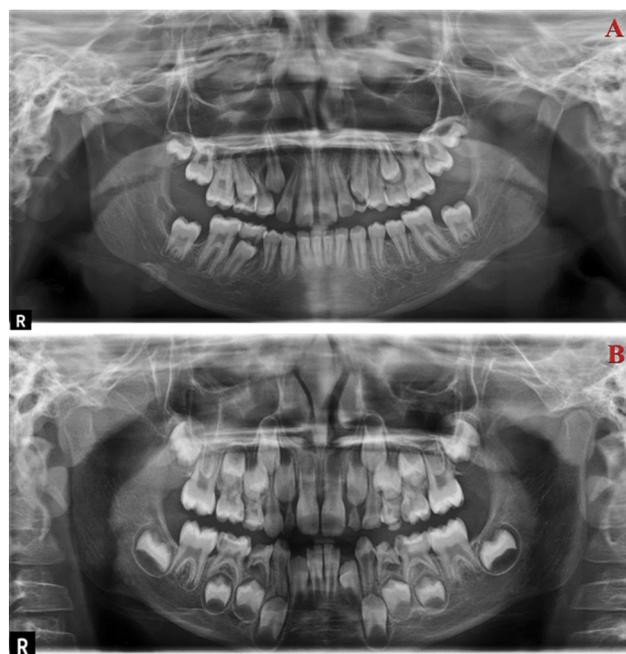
The root developmental stage was determined on panoramic radiographs of patients; A. incisors with complete root (CL); B. incisors with incomplete root.
